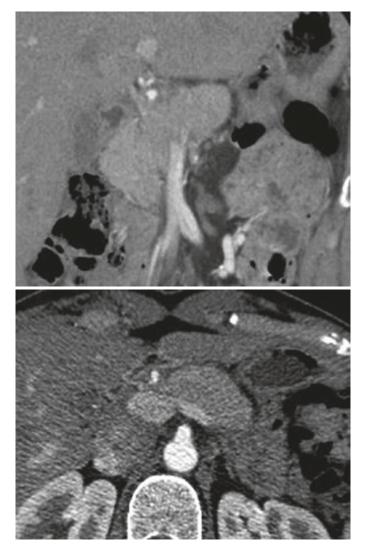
CT imaging of the pancreas revealed evidence of interstitial pancreatitis. In this case the pancreas was well perfused, edematous, without evidence of biliary or pancreatic duct dilation. Pancreatitis findings can also include indistinct pancreatic margins, peripancreatic fat stranding, and pancreatic hypoperfusion concerning for necrosis
